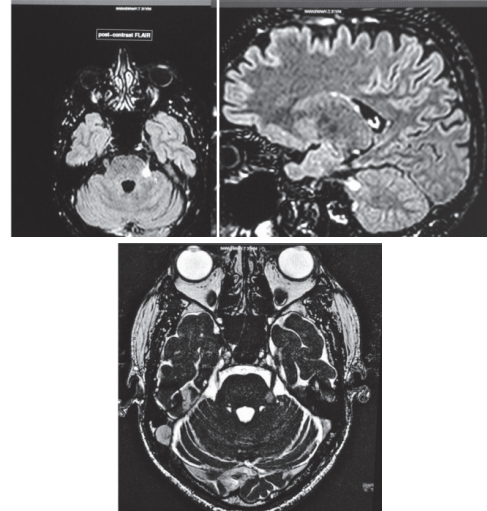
MRI Brain shows hyper intense lesion noted at left lateral part of pons at the origin of trigeminal nerve which is enhancing after contrast administration on post contrast FLAIR axial and sagittal views. Fig 11: MRI Cranial nerve sequence showing left trigeminal nerve root entry demyelination respectively.
